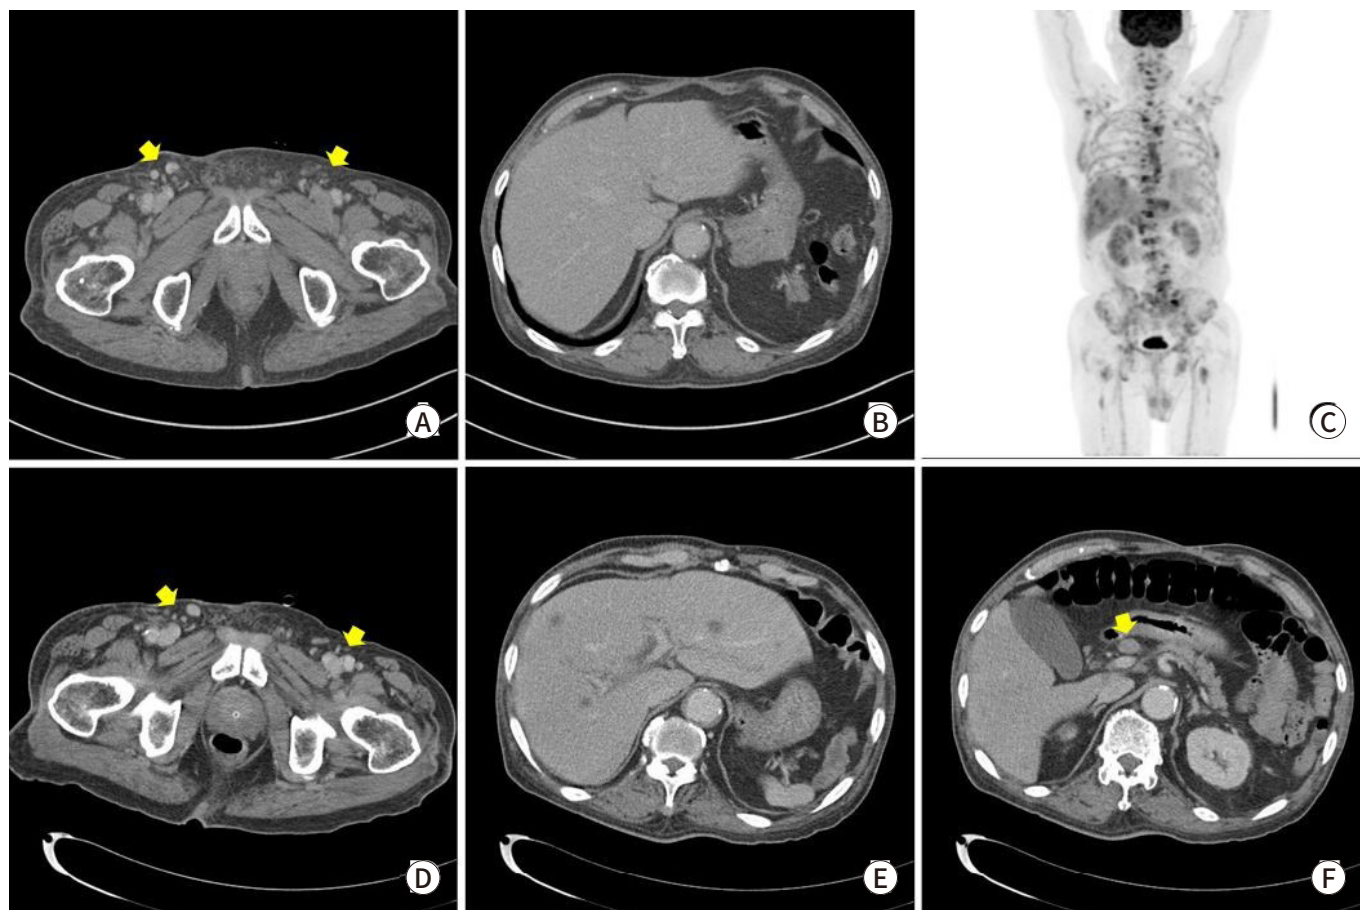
Radiologic findings. (A) Abdomen CT reveals diffuse skin thickening and subcutaneous infiltration at right inguinal and pubic area with lymphadenitis at recurrence (arrows), (B) no other visceral lesion at Abdominal CT of recurrence, (C) FDG-PET CT of after 2 months. (D–F) Abdominal CT after 2 months.
